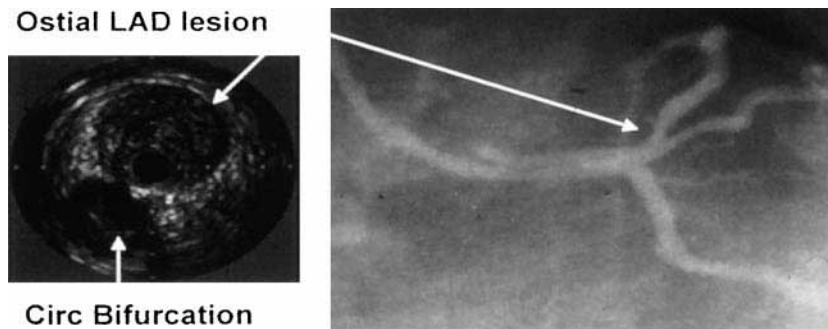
The angiogram at baseline revealed an eccentric stenosis at the ostium of the LAD that was not dramatic by angiography. However, the IVUS exam showed that there was extensive eccentric plaque that surrounded the ultrasound catheter and extended up to the bifurcation with the circumflex artery. In addition, the takeoff of the LAD was tortuous, which could make placement of a stent more difficult. A Palmaz-Schatz stent was hand crimped onto a balloon and was placed in the ostium of the LAD under fluoroscopic guidance.
